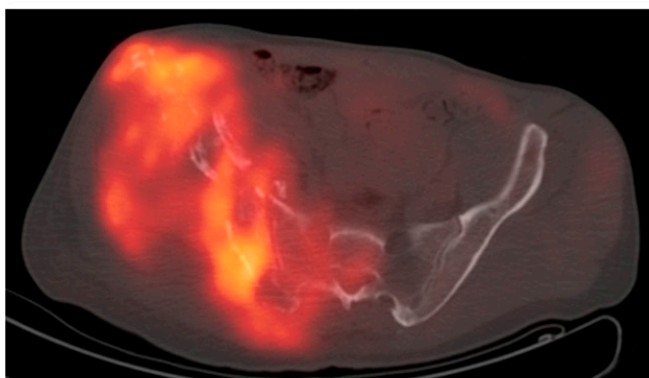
(a) Axial CT, (b) 18-fluorodeoxyglucose (^{18}F FDG)-positron emission tomography (PET) and (c) fused ^{18}F FDG-PET-CT images through the pelvis, in a patient with hereditary multiple exostoses presenting with worsening right hip pain. The right iliac bone is involved by an aggressive process with avid ^{18}F FDG uptake compatible with a chondrosarcoma.
